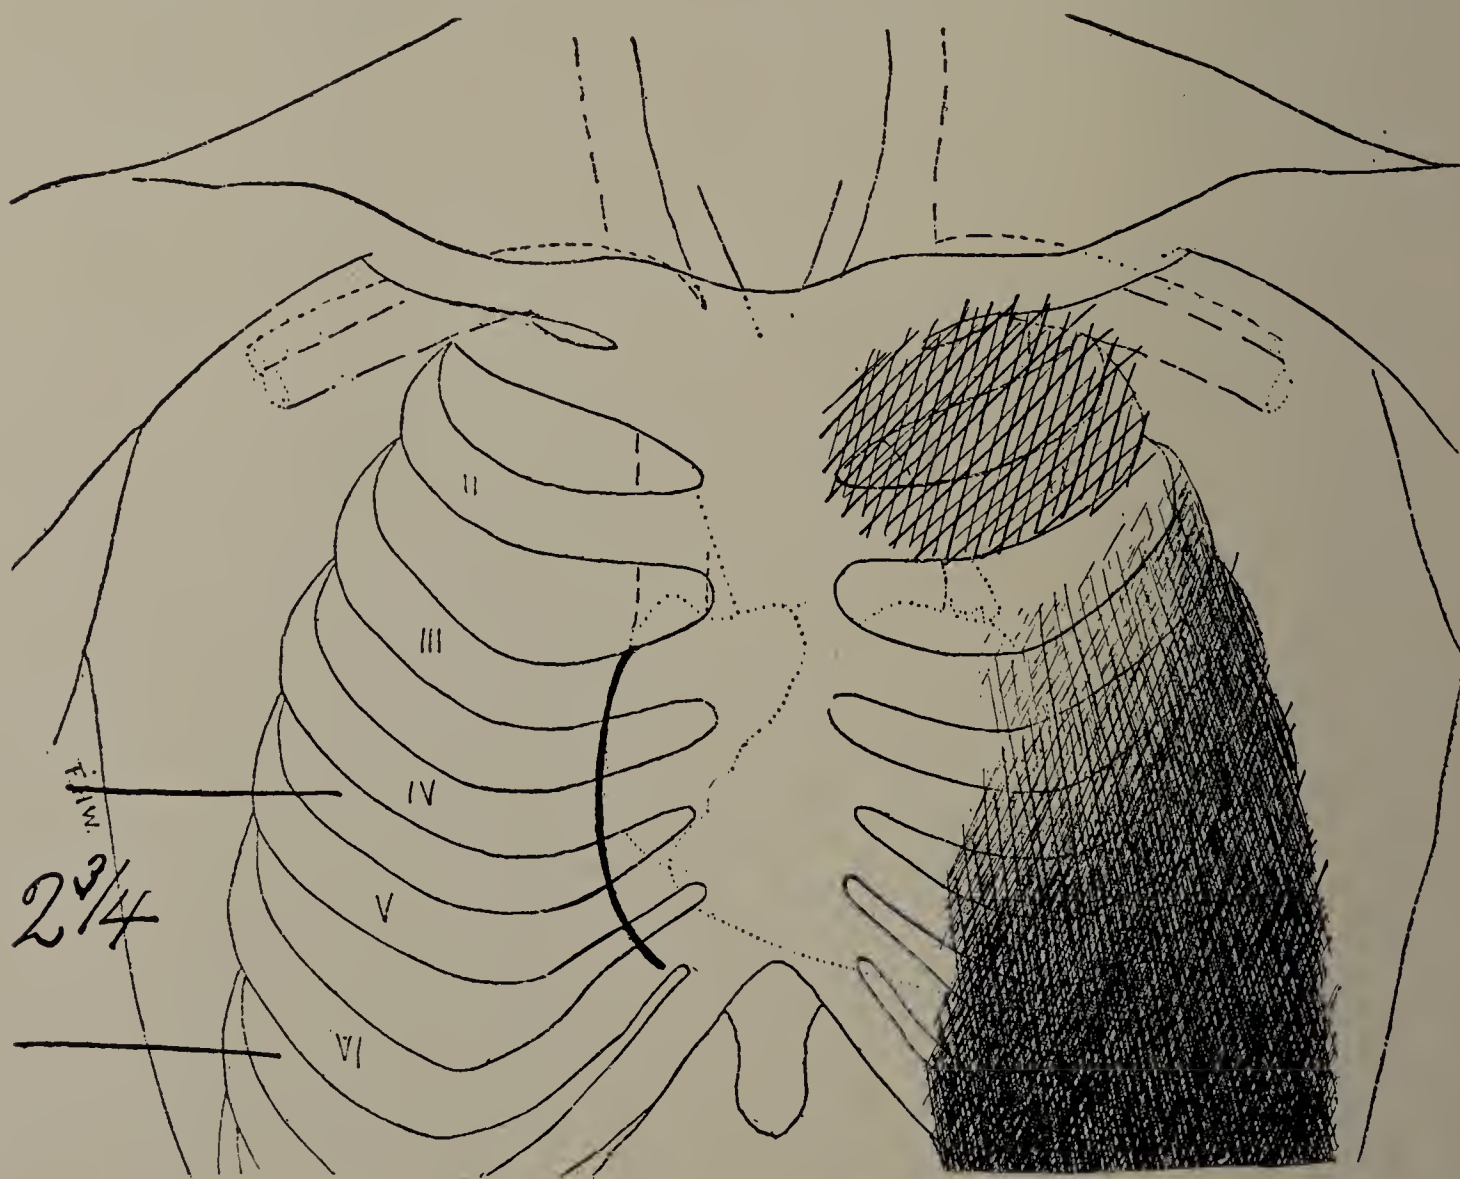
Mary F. May 12. Second X-ray examination with screen. Less effusion in left chest. Darkened left apex from tuberculosis. Light area seen between the effusion and darkened apex. Excursion of diaphragm on right side 7 centimetres greater than at first examination. (Cut one-third life size.)
